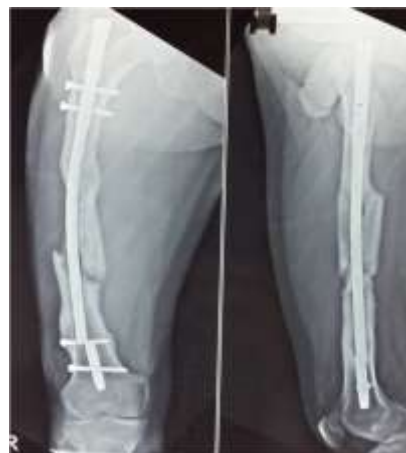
(a): AP and Lateral radiographs of femur with broken nail
